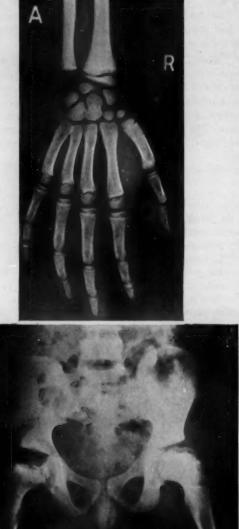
A, roentgenogram of the right hand. The bones show increased radiolucence and delayed development of the radial and ulnar styloid epiphyses. The appearance of the epiphyses in general is not that of true rickets.
